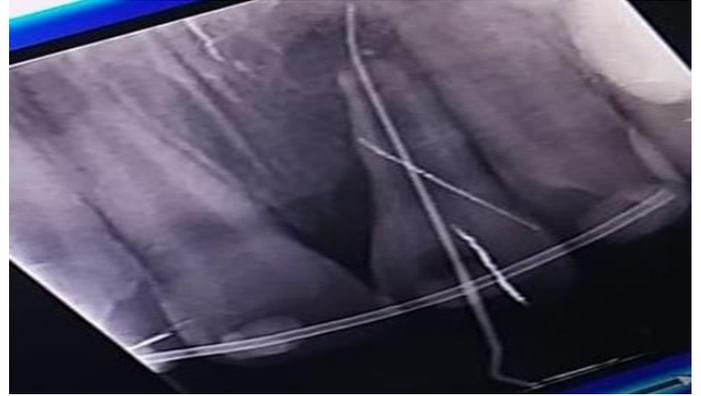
Radiographic image of working length determination.
